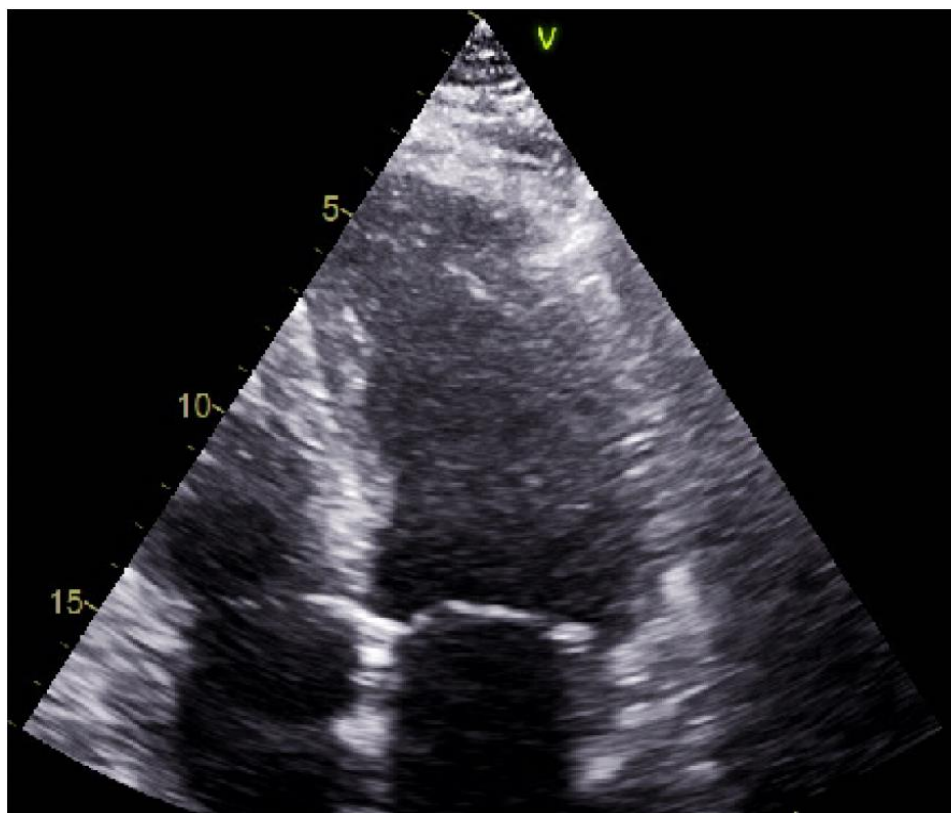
Echocardiographic evidence of systolic dysfunction following CABG with LVEF approximately 10-15%.
